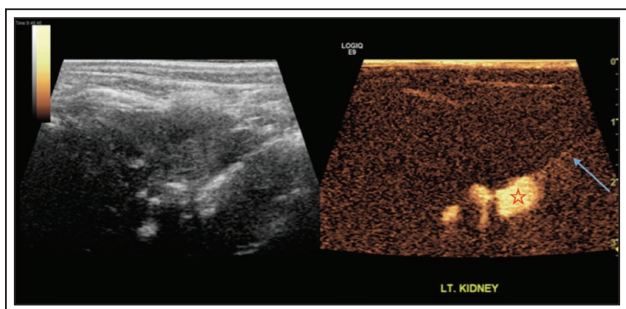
Percutaneous nephrostogram utilizing a second generation ultrasound contrast agent defining the collecting system and confirming needle access into the collecting system. (Star indicating interpolar minor calyx, arrow indicating the access needle).
